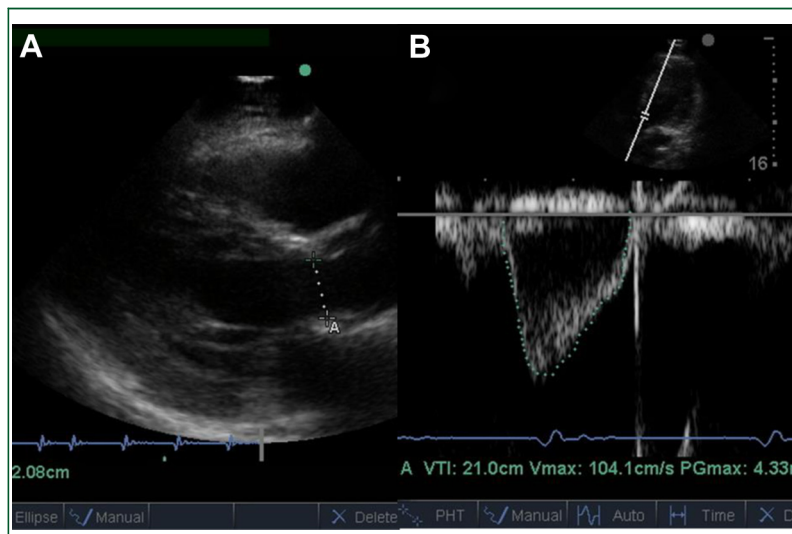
Estimating cardiac output using transthoracic echocardiography. (A) Measuring the LVOT diameter from the parasternal long-axis view. (B) Using pulsed wave Doppler to measure the velocity-time integral at the level of the LVOT. LVOT, left ventricular outflow tract.
